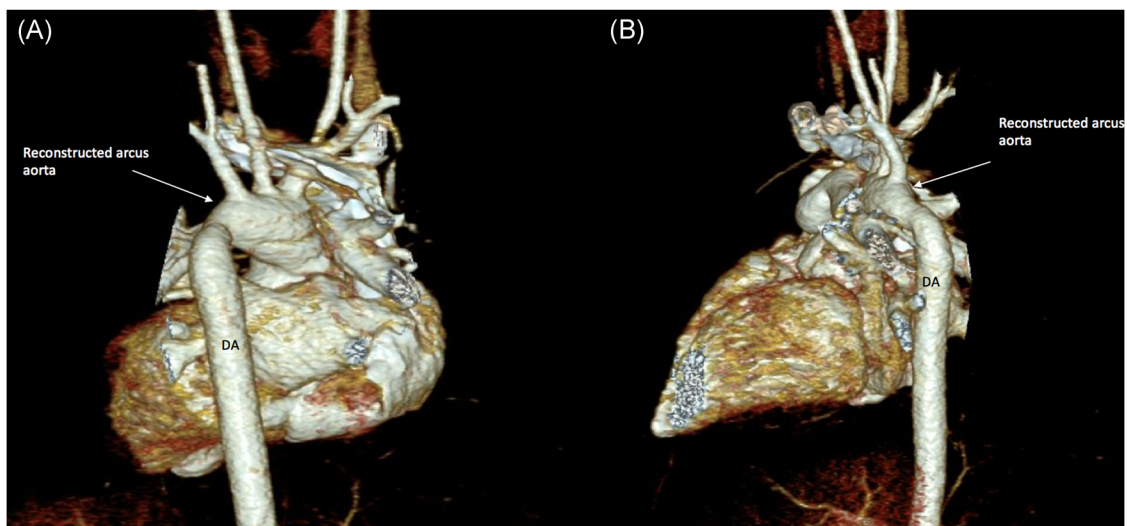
Postoperative CT scan at the 6th month with a 3-D reconstruction of a neonate who underwent arterial switch and aortic arch reconstruction operation because of Taussig Bing anomaly with AAH viewed laterally (A, B). AAH, aortic arch hypoplasia; CT, computed tomography; DA, descending aorta.
